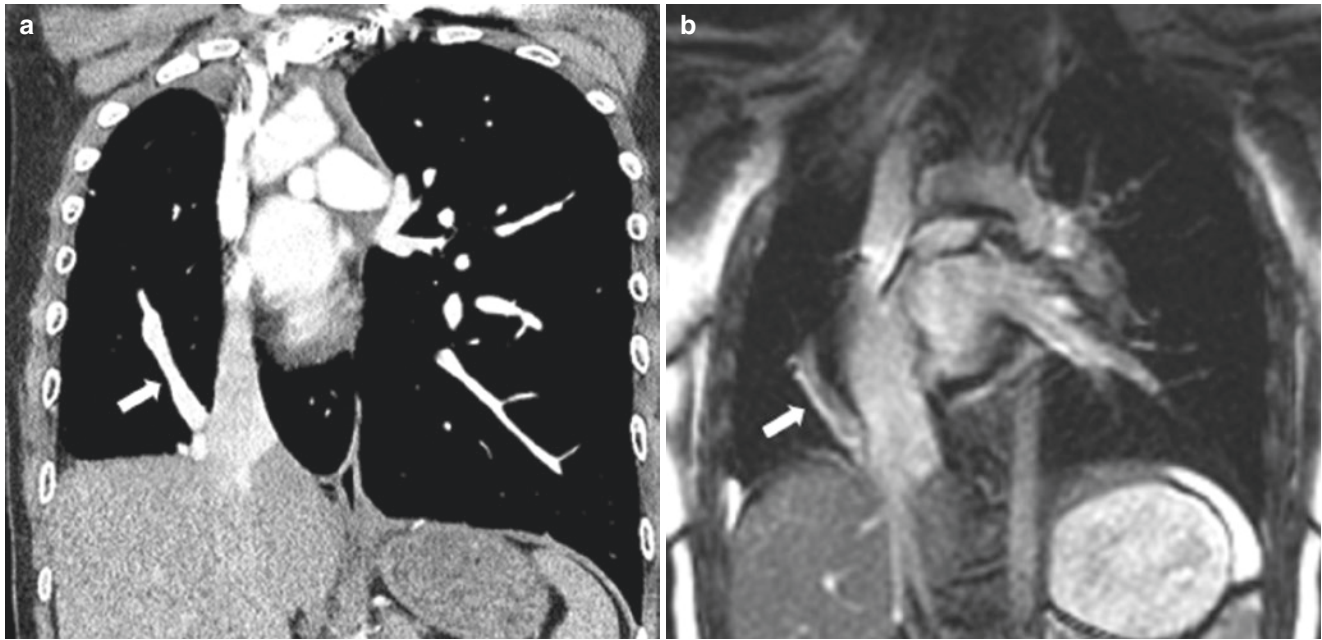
A 11-year-old girl with scimitar syndrome. (a) Coronal contrast-enhanced CT image demonstrates a hypoplastic right lung drained by an anomalous vein (arrow) which is connected to the inferior
